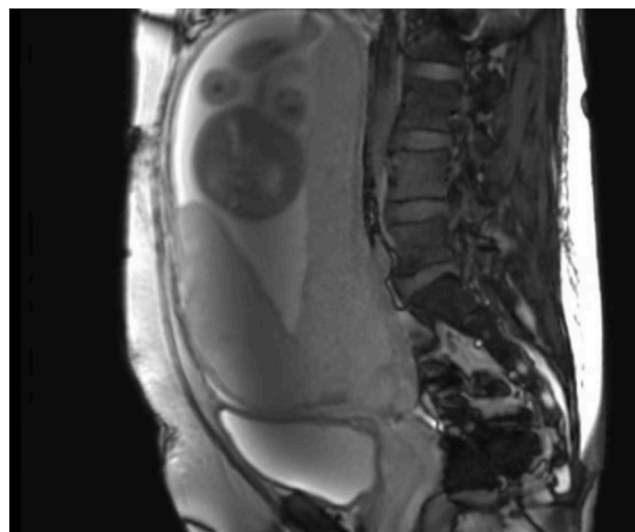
Non-contrast MRI abdomen/pelvis at 23 week's gestation. Large focal bulge in the posterior inferior aspect of the placenta in the lower uterine segment and no visible myometrium surrounding the placenta in this region. The placental tissue in this region is heterogeneous and associated with a low signal band.
